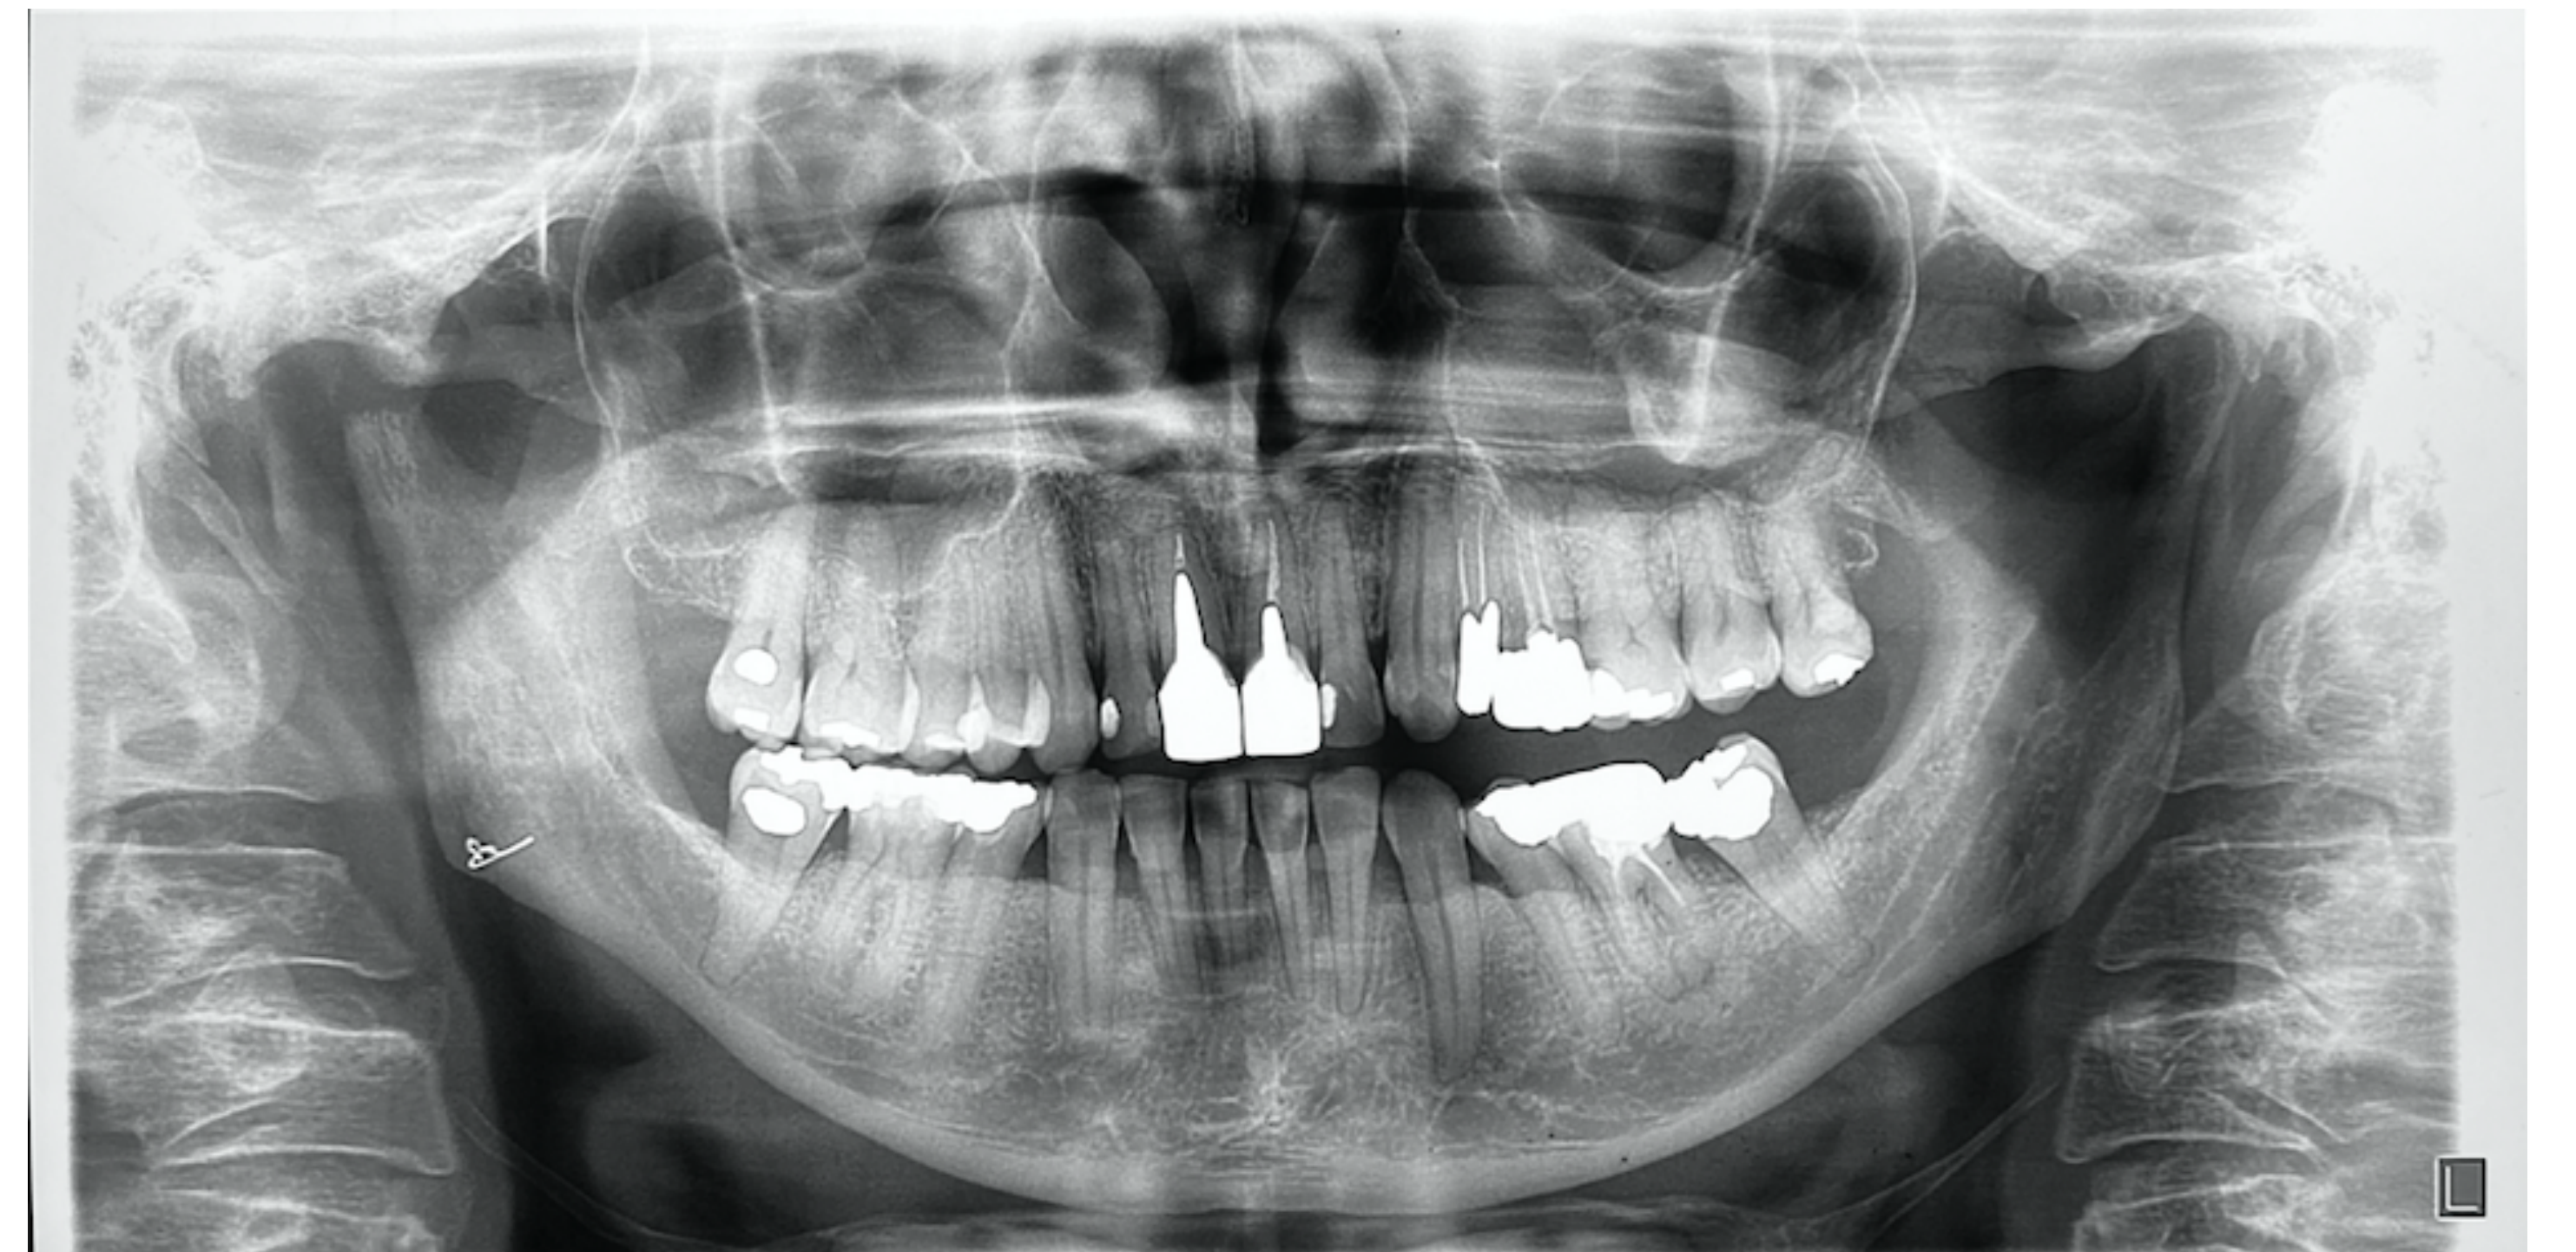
Postoperative panoramic radiography revealing the low condylectomy performed and the gap from the mandibular fossa.
